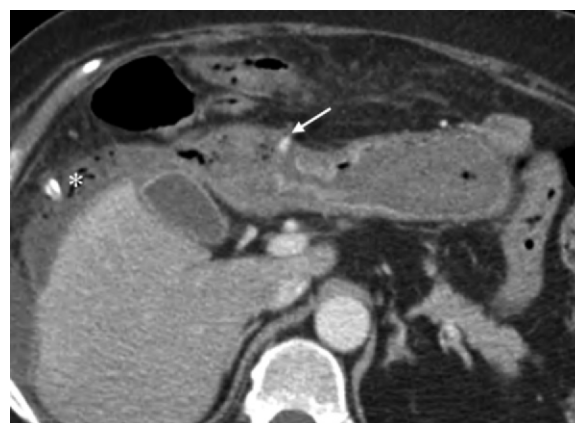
Hemorrhagic gastric ulcer in a patient who presented with abdominal pain and hematemesis. Axial CT image with intravenous contrast material demonstrates active extravasation (arrow) at the site of a perforated gastric antral ulcer, with adjacent fluid and air collections (*).
